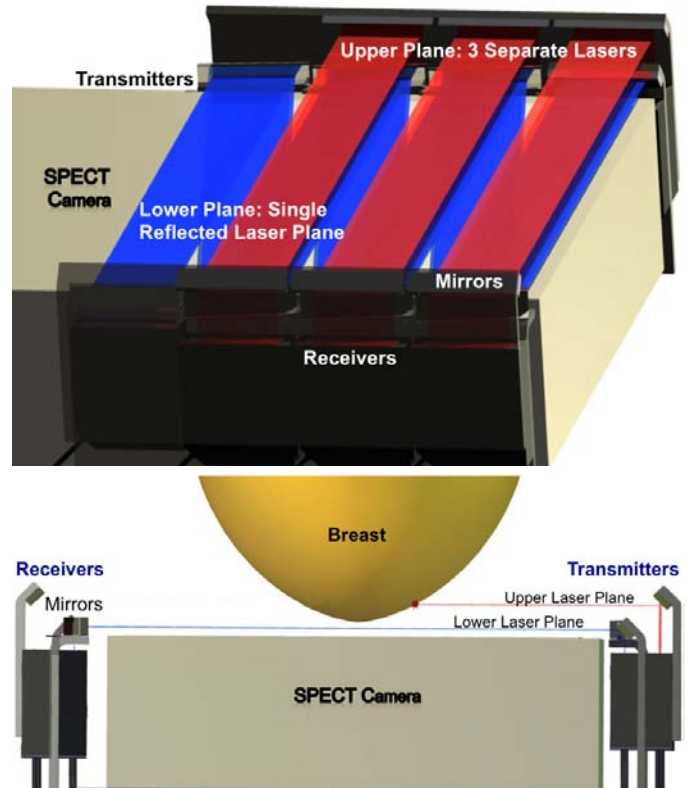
(TOP) Automated breast surface contouring implementation using a dual-layer, low divergence, ribbon laser feedback sensor system mounted along the edges of the SPECT camera. The upper sensor layer (shown above in red) consists of three laser-detector pairs that identify the region on the camera face that has been penetrated, while the lower layer (shown above in blue) consists of a single, multiply reflected beam defining a virtual plane. (BOTTOM) Side view of the SPECT camera with breast penetrating the upper optical sensor plane.
